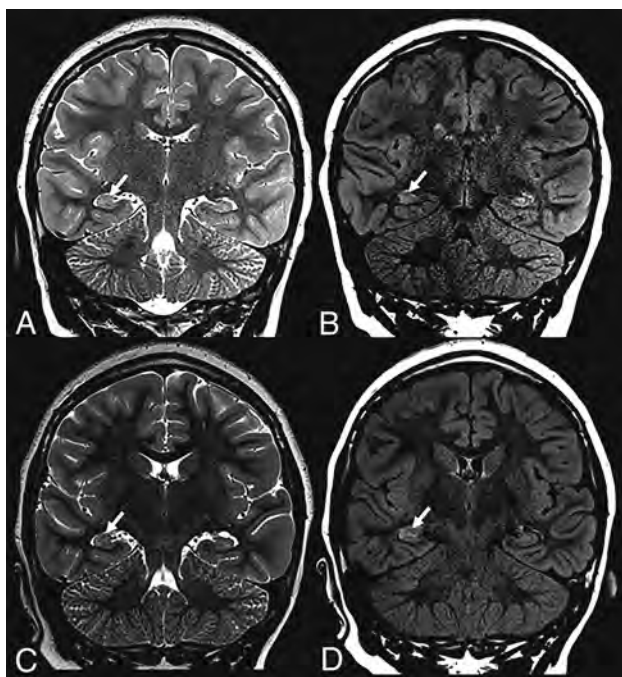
A previously healthy 9-year-old girl who presented with status epilepticus tested positive for SARS-CoV-2. Brain MR imaging showed subtle right hippocampal T2-FLAIR signal alteration with corresponding edema (arrows) on initial (upper row) and follow-up (lower row) imaging.
